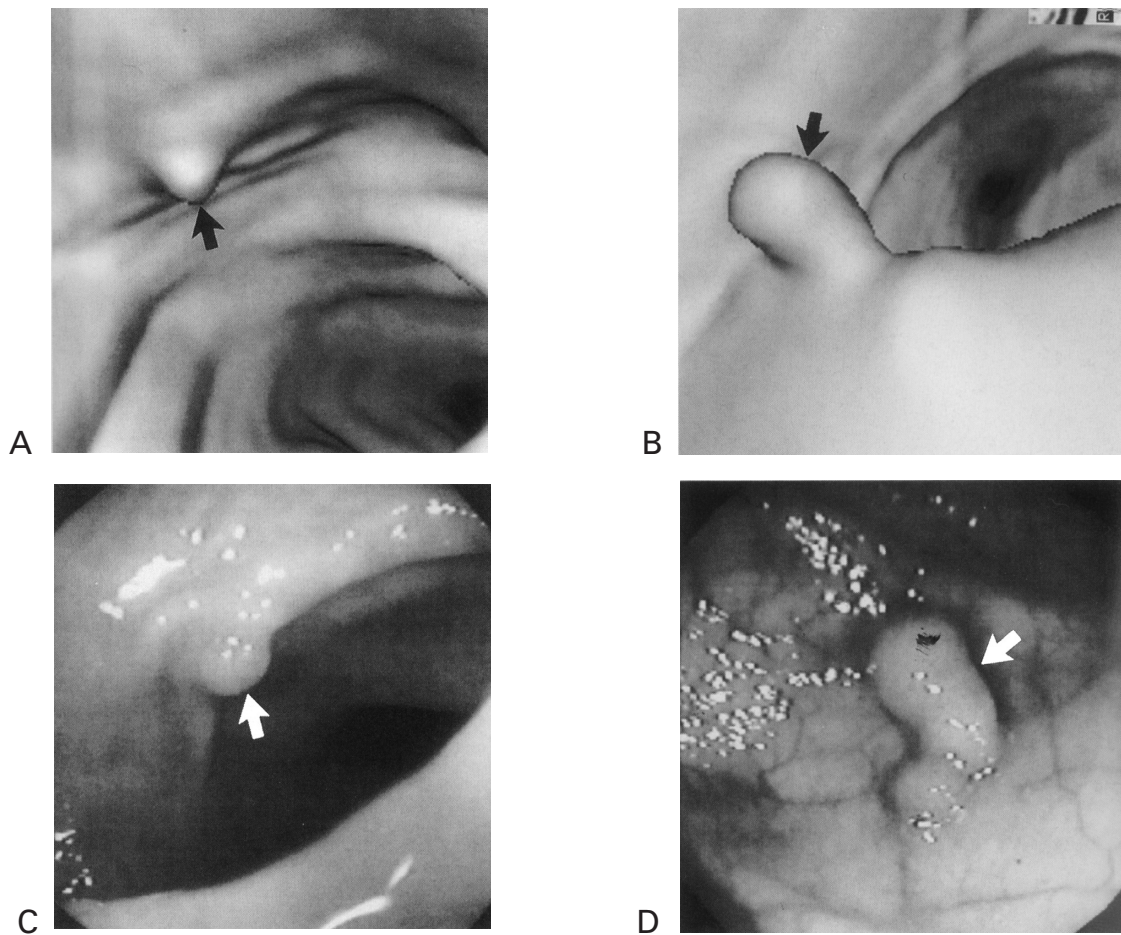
Findings from computed tomography (CT) virtual colonoscopy images (A, C) compared with corresponding colonoscopic photographs (B, D). Adapted with permission from the Radiological Society of North America (24), (*Radiology* 2001; 219:685-692).
